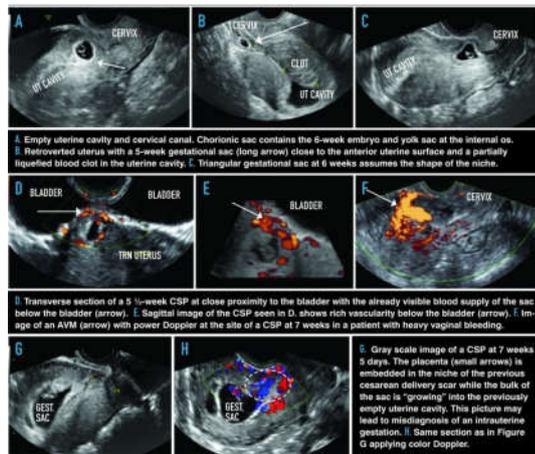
Pictorial summary of sonographic markers of CSP
